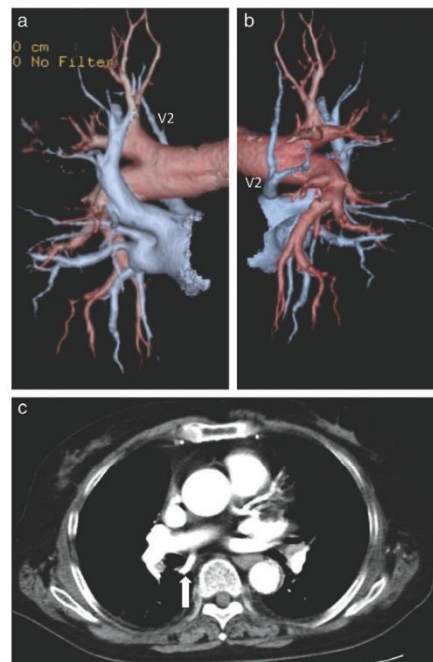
Abnormal distribution of the aberrant pulmonary vein (V²) descended dorsally and emptied into the left atrium. (a) Front view; (b) right side view. (c) V2 (white arrow) behind the right main bronchus independently drained directly into the left atrium, observed on two-dimensional computed tomography.
